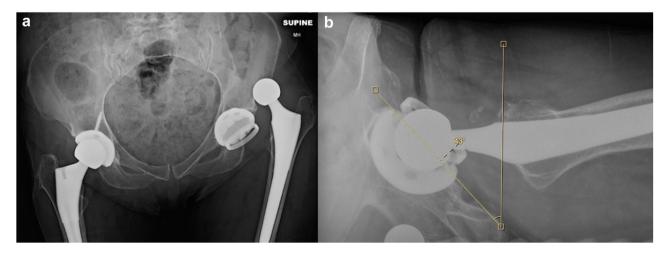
(a) Anteroposterior radiograph of the pelvis at initial presentation showing a posterior dislocation of the femoral component. (b) Cross-table lateral radiograph of the left hip after the patient's first revision surgery. Acetabular component anteversion was measured using the Woo and Morrey Method as the angle formed when a tangential line to the opening of the acetabulum and a line drawn perpendicular to the horizontal edge of the radiograph intersect.
